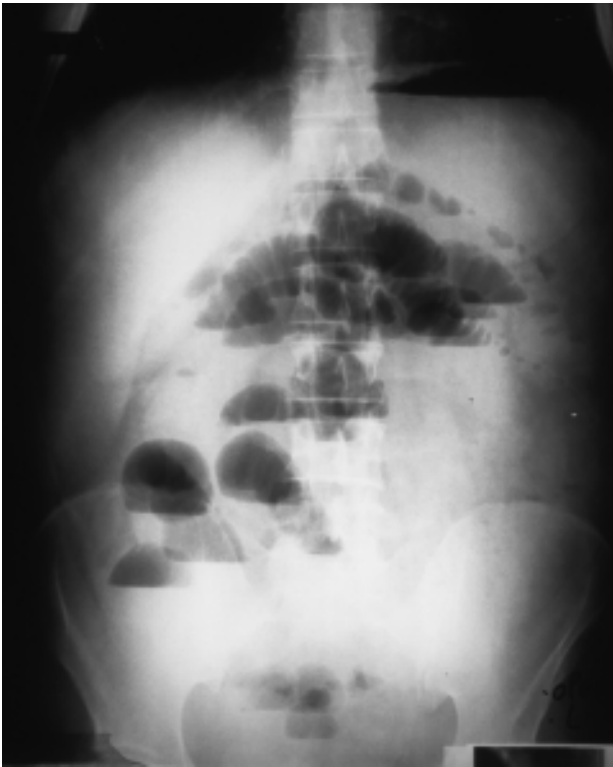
Plain film indicative of small bowel obstruction.
